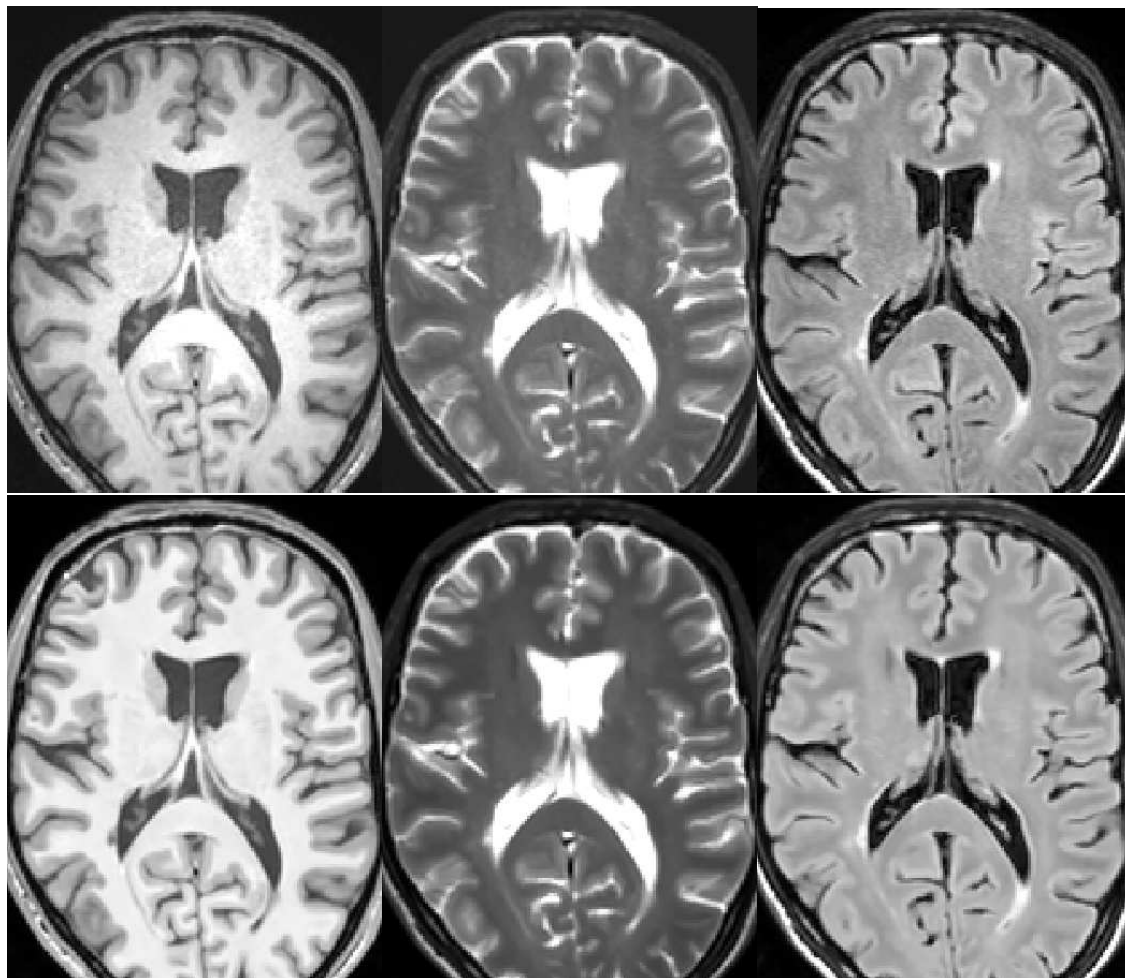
Preprocessing results of patient 5 from the Rennes database. Top line, from left to right: original T1-w, T2-w and FLAIR. Bottom line, form left to right: processed T1-w, T2-w and FLAIR.
